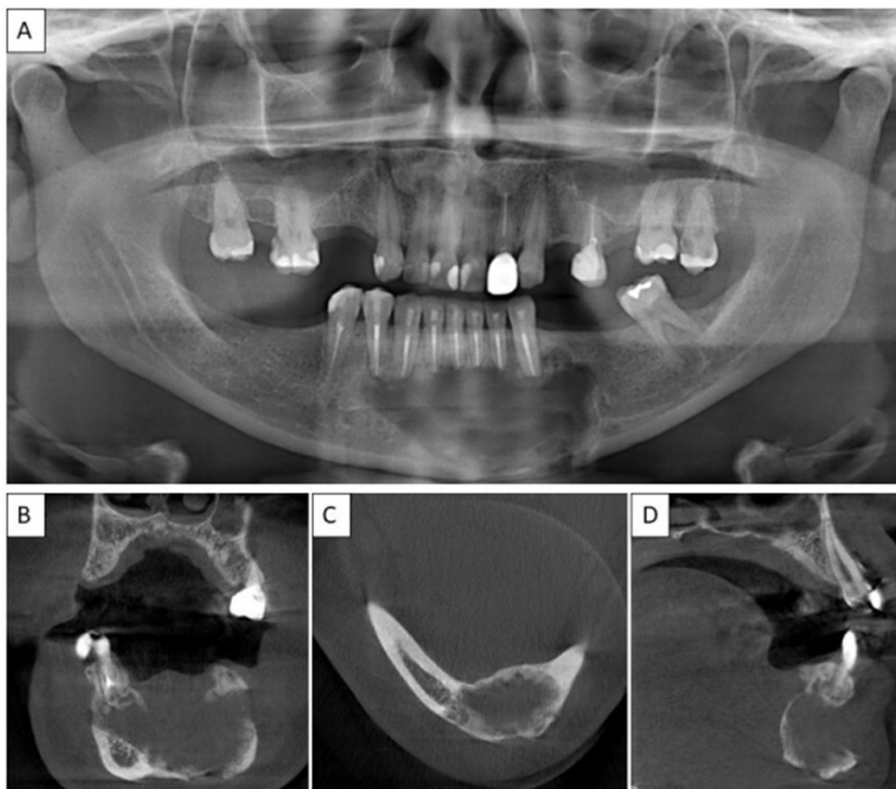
A) Three-months postoperative panoramic radiograph, with bone neoformation; three-months postoperative cone beam CT: B) Coronal section; C) Axial section; D) Sagittal section, bone neoformation.
